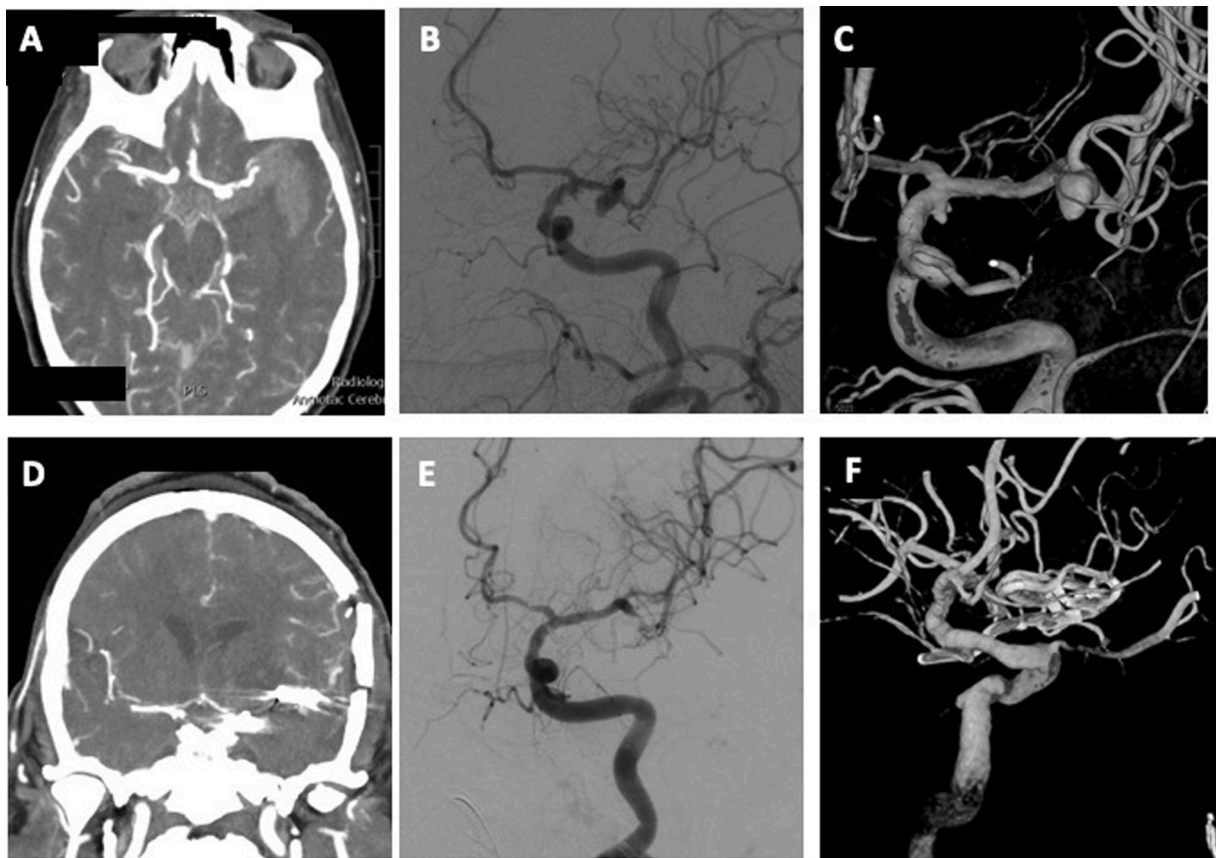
Case 15 – 40-year-old female presented with a Fisher grade 3 subarachnoid hemorrhage (A). Preoperative diagnostic angiogram demonstrated the presence of a bi-lobulated wide neck anterior choroidal aneurysm and a 7 mm aneurysm located in the bifurcation of the middle cerebral artery (B and C). Postoperative CT angiogram (D) and digital subtraction angiography (D and E) confirmed the complete occlusion of the aneurysms.
